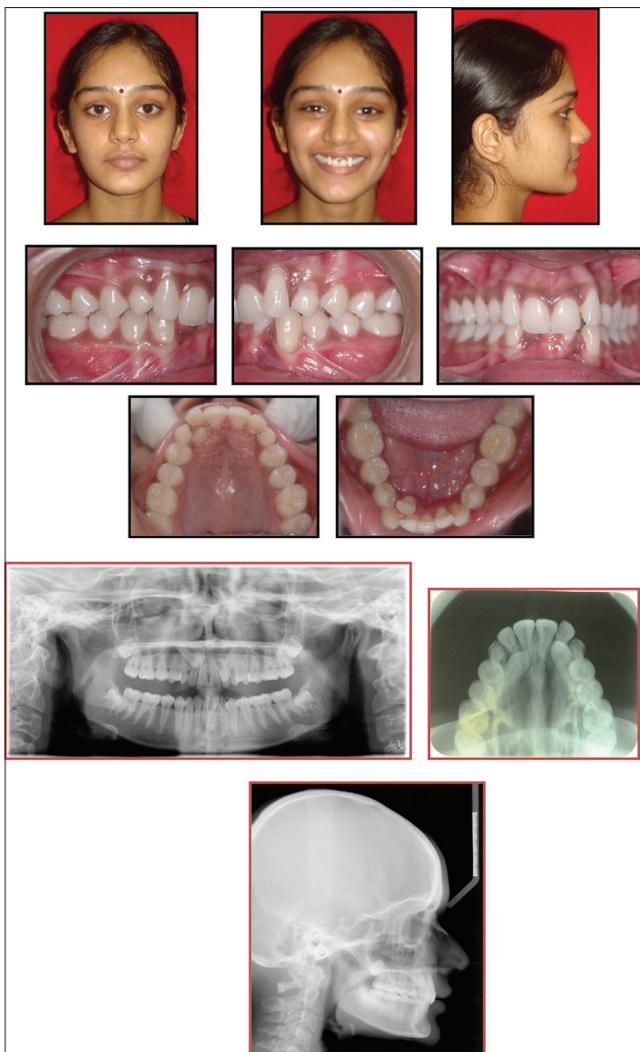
Pretreatment extraoral and intraoral photographs and radiographs
